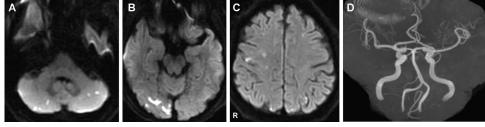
Brain magnetic resonance image on admission. Diffusion-weighted image shows hyperintense lesions, indicating an acute infarction in the right occipital lobe and the bilateral anterior lobe, the parietal lobe, and the cerebellar hemisphere (A-C). Magnetic resonance angiography showed no evidence of stenosis or occlusion of the carotid or intracranial arteries (D). Abbreviation: R, right.
